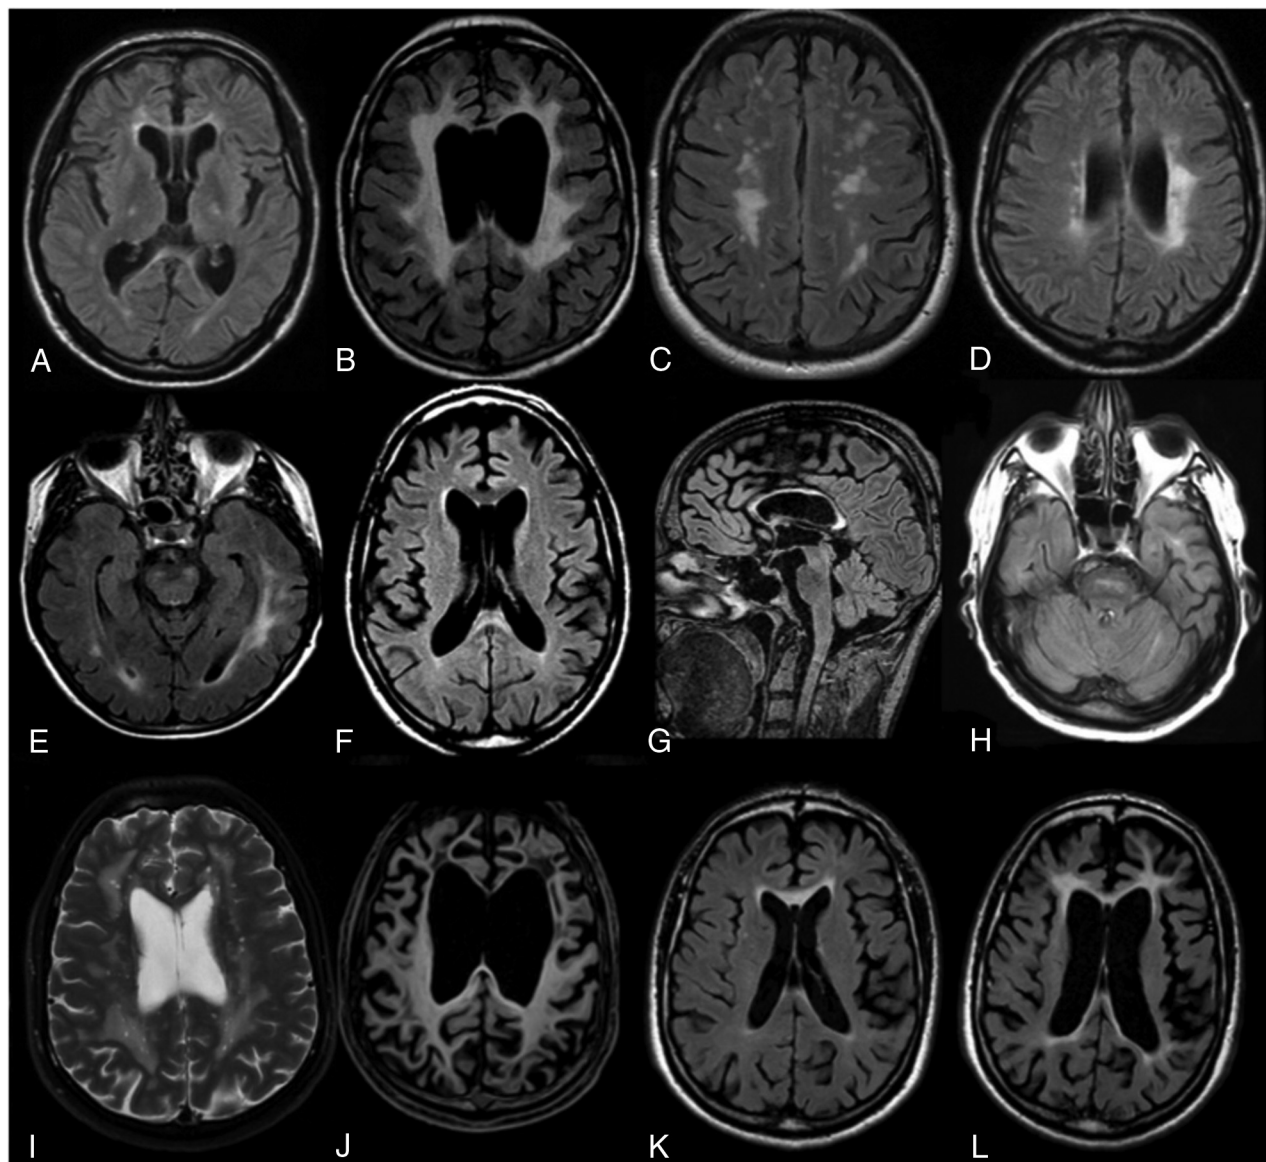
Characteristic MR imaging abnormalities in patients with ALSP on FLAIR (A–H, K, L), T2WI (I), and T1WI (J) images. MR imaging usually discloses subtle (A) or marked (B) white matter hyperintensities with frontal predilection (B). WMH can be confluent (B) or patchy (C) and are usually asymmetric (D). Corticospinal tract involvement (A and E) and corpus callosum involvement (F and G) are frequent. At the posterior fossa level, WMH can be of a vascular-like type (H). Some patients can present with enlarged perivascular spaces on T2WI (I). T1WI frequently reveals atrophy, usually marked, with frontal predominance (J). During a 32-month follow-up (case 8), a clear increase of WMH and atrophy is seen (K and L). A cavum septum pellucidum is frequently observed (A and B).
